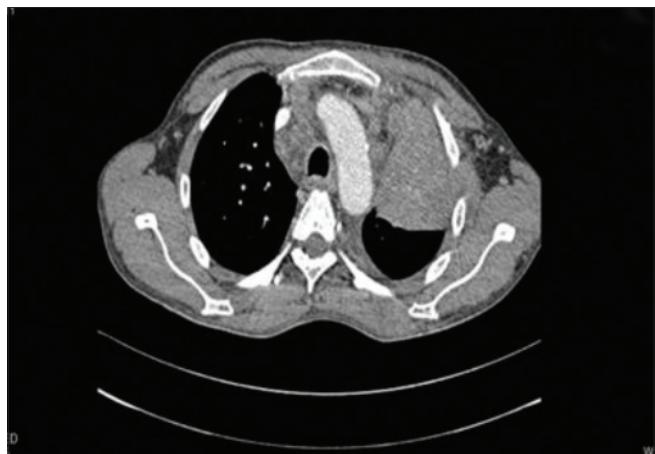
CT Thorax showing lung malignancy in anterior segment of left upper lobe
